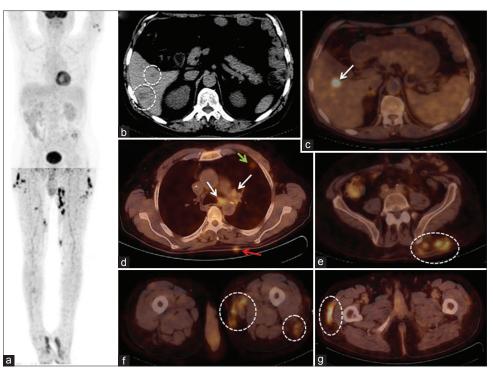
(a) Fluorodeoxyglucose-positron emission tomography maximum intensity projection image demonstrates multiple fluorodeoxyglucose - avid foci over the cutaneous and subcutaneous tissues. (b) Computed tomography image reveals multiple hypodense hepatic lesions (circles). Axial fluorodeoxyglucose-positron emission tomography/computed tomography images demonstrate fluorodeoxyglucose - avid lesions in (c) liver (maximum standardized uptake value: 9.8) (arrow), (d) multiple lymph nodes in the mediastinum and hilum (maximum standardized uptake value: 2.9) (white arrows), peripheral left lung (green arrow), cutaneous left paraspinal region (red arrow), (e) cutaneous tissue over the left posterior pelvic region (oval), (f) soft tissue over the left leg (circles), and (g) subcutaneous tissue of the right thigh (maximum standardized uptake value: 6.7) (oval)
